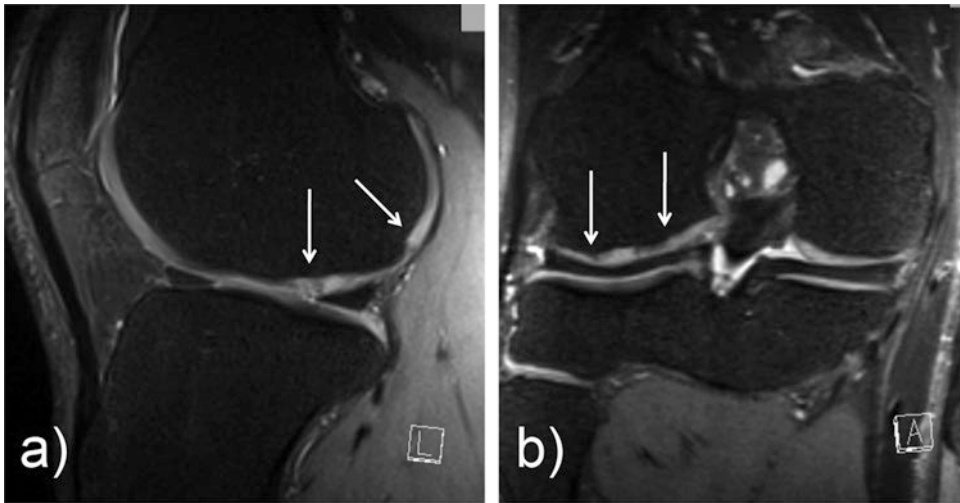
Sagittal (a) and coronal (b) MR images acquired with a 3D-SPACE of the femoral condyle of a patient were obtained 36 months after microfracture therapy.
